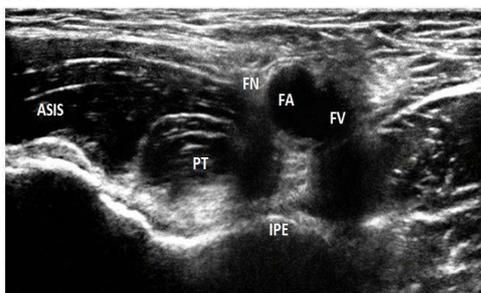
Ultrasound-Guided Pericapsular Nerve Group (PENG) Block Group
